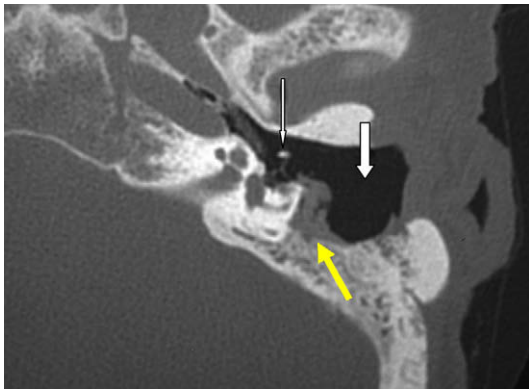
Axial CT following open tympanomastoidectomy. Note absence of the posterior canal wall (*thick white arrow*). Debris in the mastoid (*yellow arrow*) is indeterminate and could reflect cholesteatoma or inflammatory debris. The open cavity facilitates direct inspection for clarification. The malleus “handle” remains (*thin white arrow*) and there is a type 3 tympanoplasty, the TM articulating directly with the stapes capitulum.
